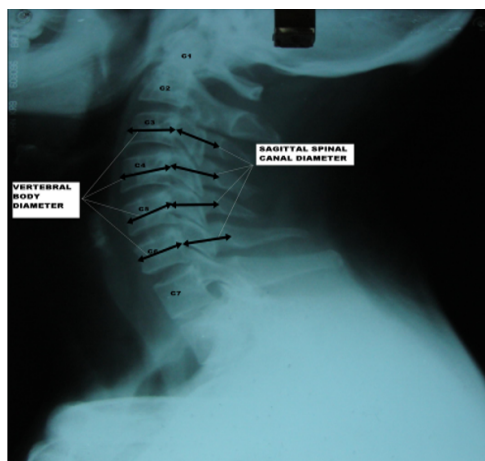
Lateral radiograph of the cervical spine
